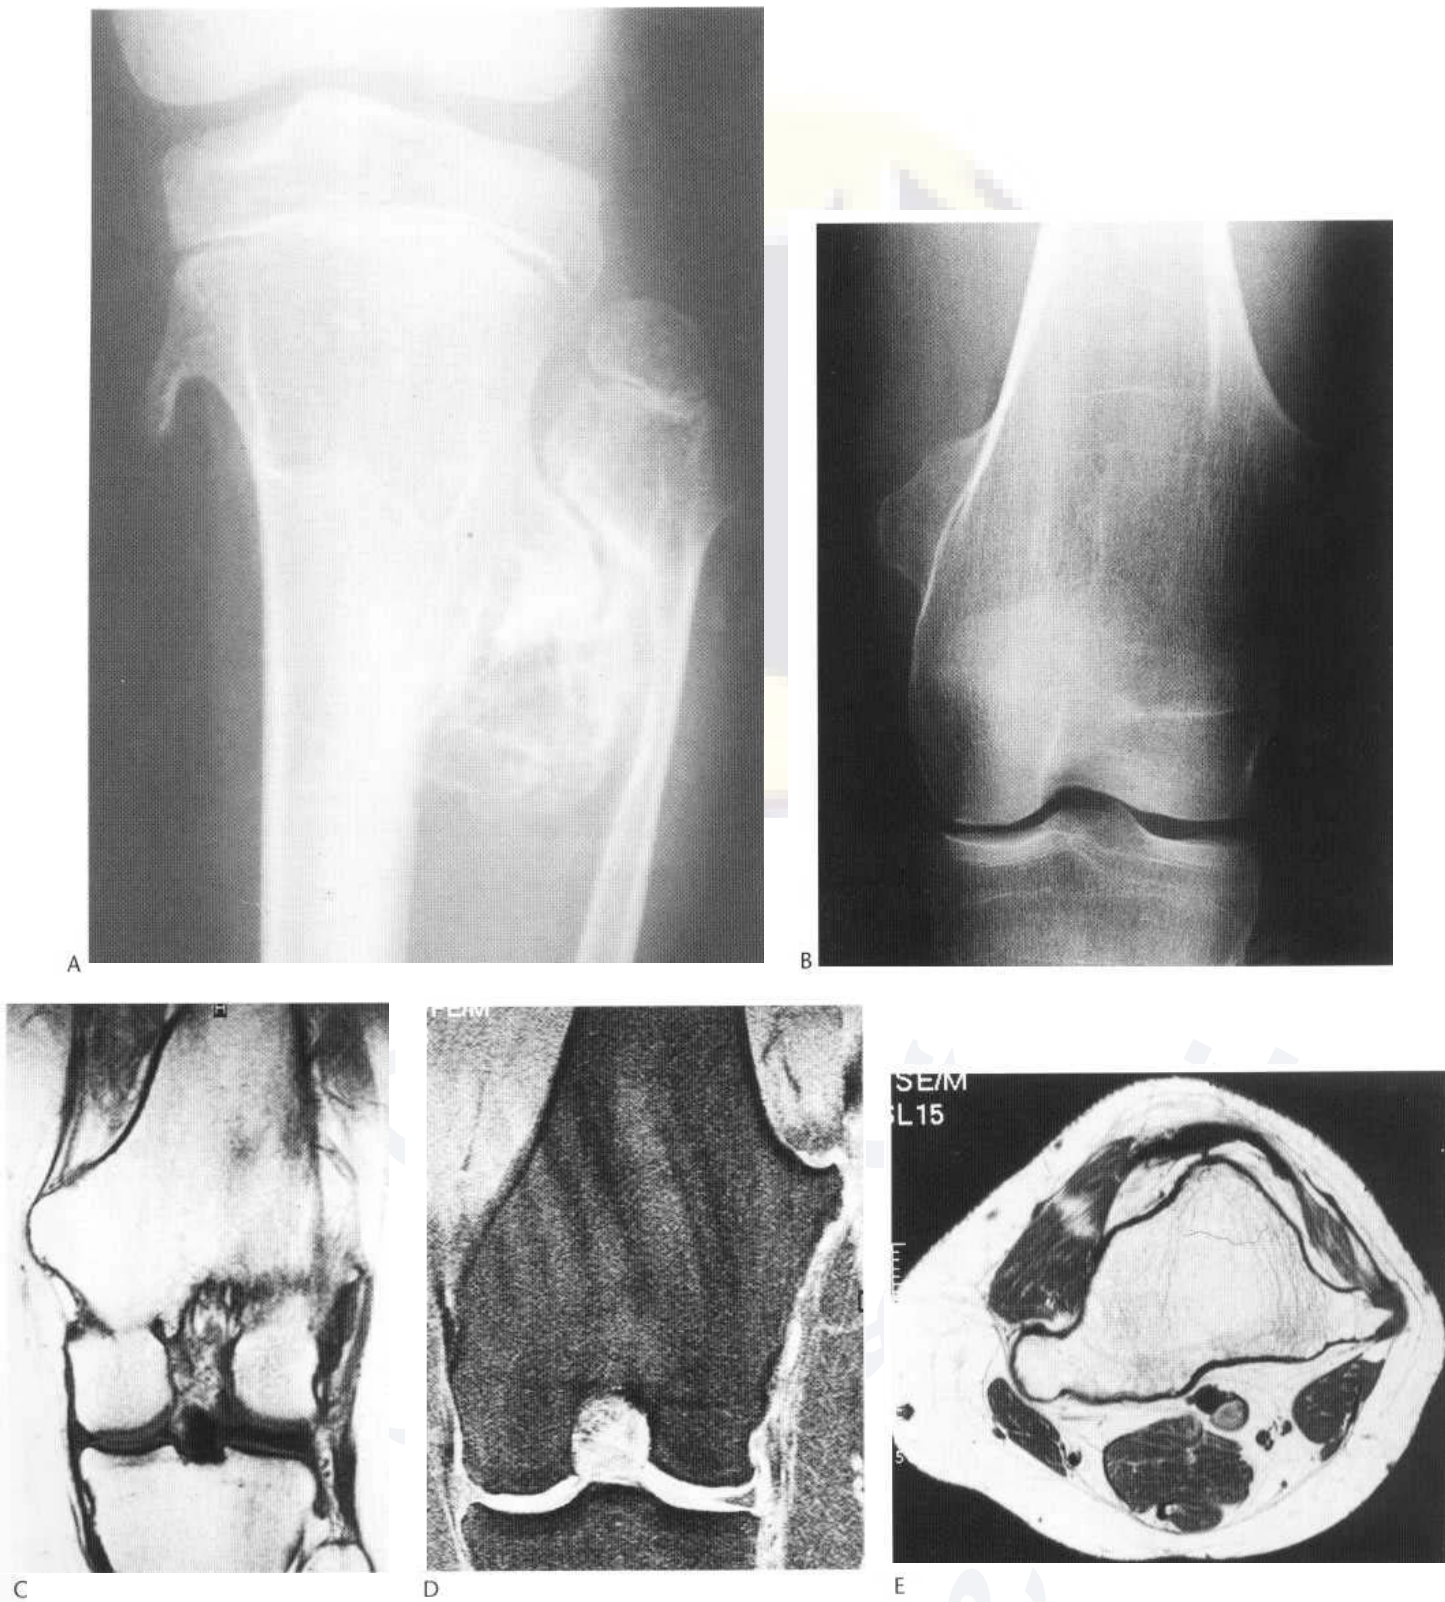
Diaphyseal aclasia. (A) Multiple osteochondromas are present in the proximal tibia and fibula. A large sessile lesion of the proximal tibia has caused widening of the interosseous space and secondary moulding abnormalities of both the tibia and fibula. In another patient (B), similar modelling abnormalities are shown. On MRI, following ligamentous injury, only a minimal cartilage cap can be identified on the medial osteochondroma, and a slightly thicker cap on the laterally projecting osteochondroma: (C) coronal T₁-weighted, (D) coronal FFE-T₂ and (E) axial T₁-weighted images.
